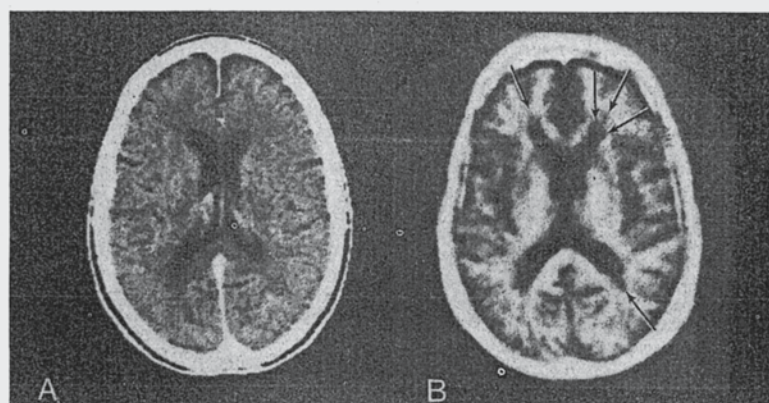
Comparable CT (A) and NMR (B) scans in patient 6 at low ventricular level.
